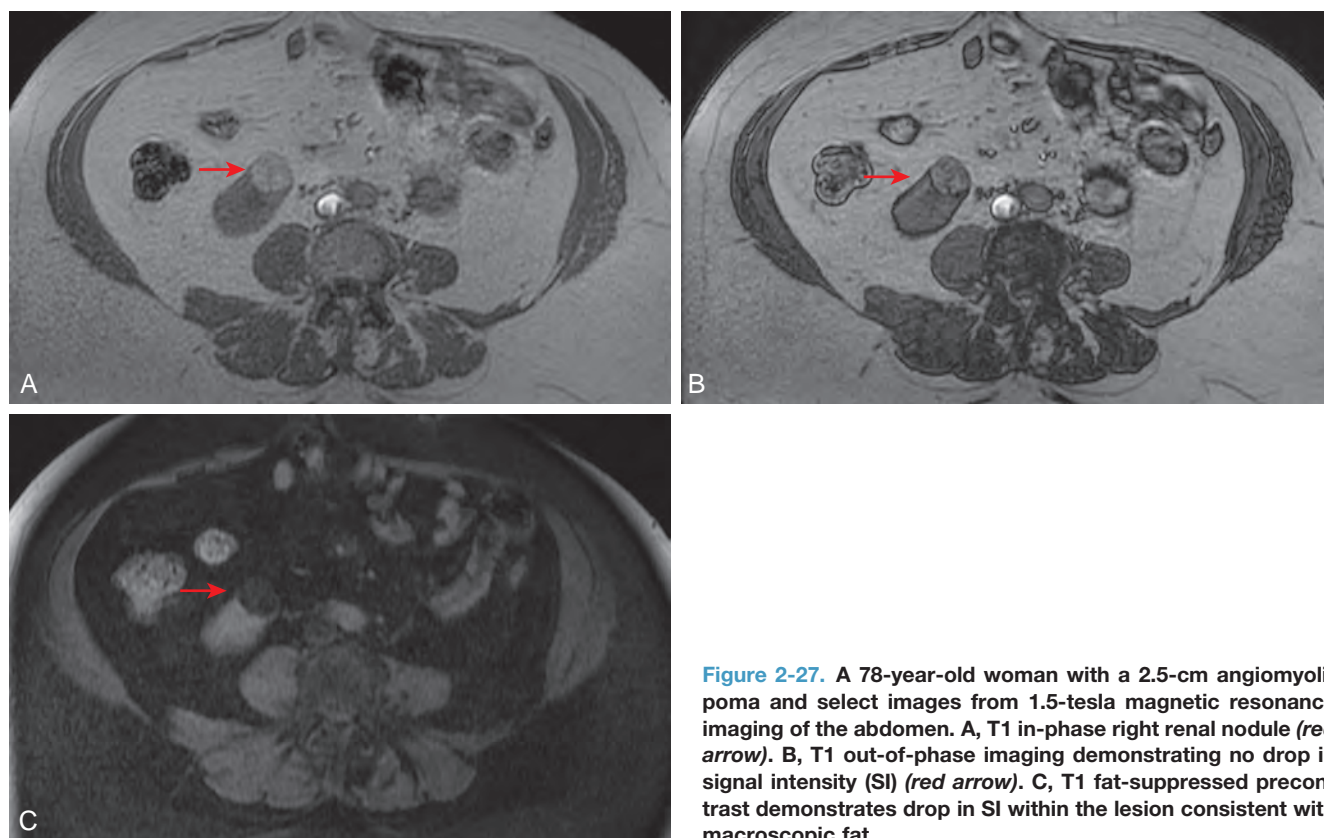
A 78-year-old woman with a 2.5-cm angiomyolipoma and select images from 1.5-tesla magnetic resonance imaging of the abdomen. A, T1 in-phase right renal nodule (red arrow). B, T1 out-of-phase imaging demonstrating no drop in signal intensity (SI) (red arrow). C, T1 fat-suppressed precontrast demonstrates drop in SI within the lesion consistent with macroscopic fat.
